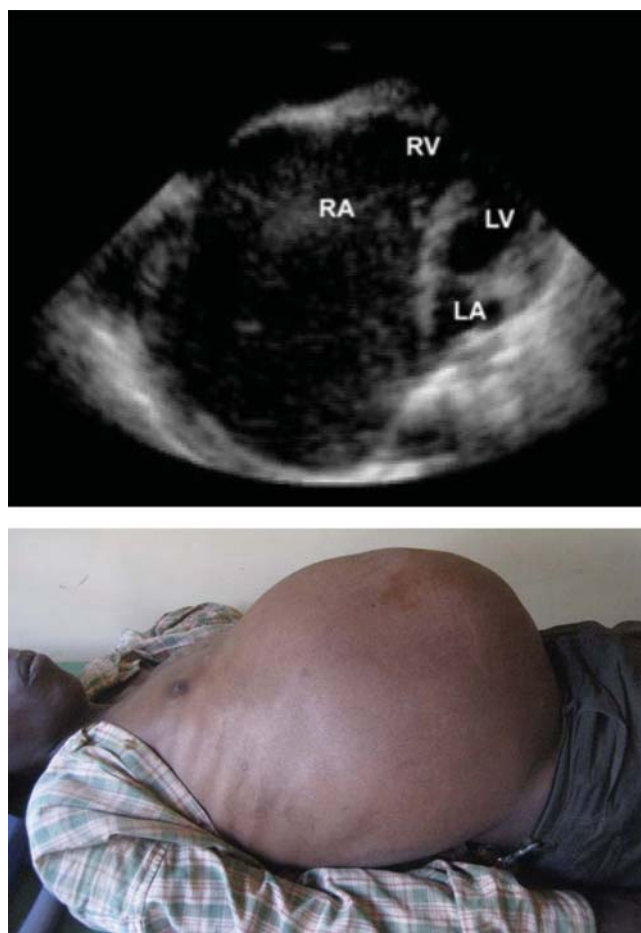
Top, echocardiogram in a 25-year-old man with predominantly right ventricular EMF from eastern Rwanda. Apical four-chamber view. Note the marked dilatation of the right atrium. RV = right ventricle, RA = right atrium, LV = left ventricle, LA = left atrium. Bottom, massive ascites in the same patient.
